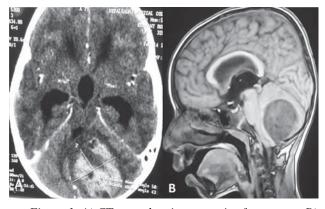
A) CT scan showing posterior fossa mass, B) MRI showing the cerebellar lesion
